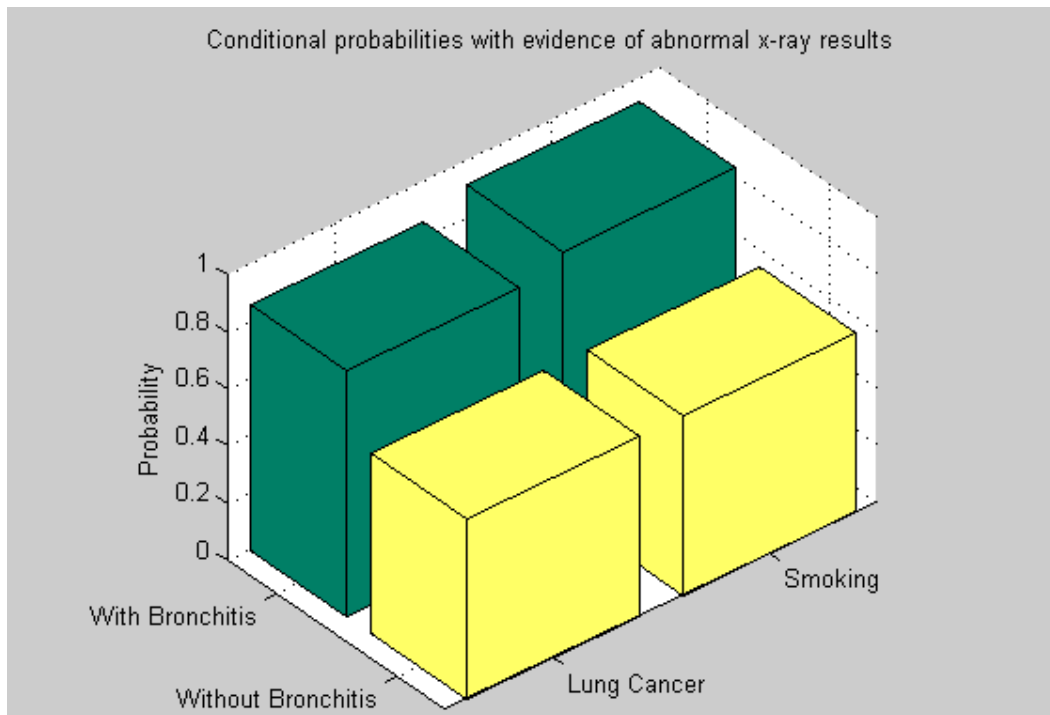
Conditional probability with evidence of abnormal x-ray Result
